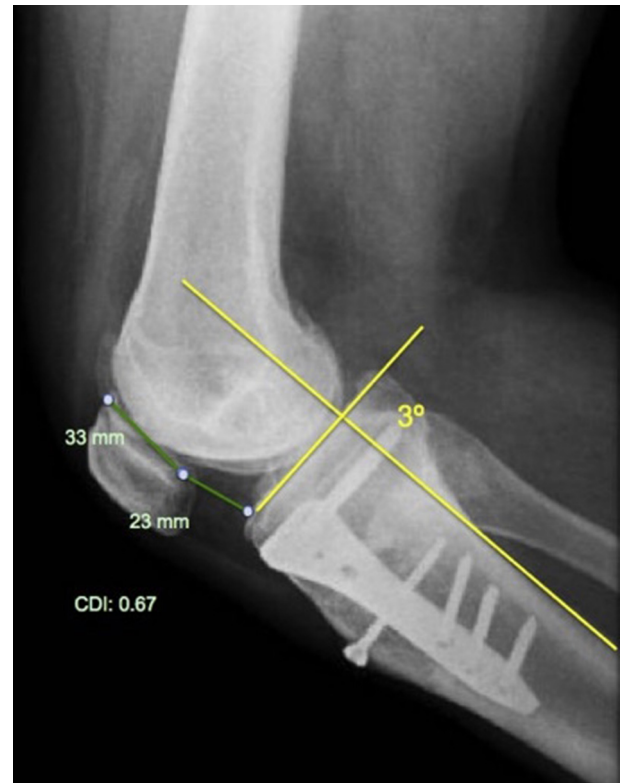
Postoperative radiographic sagittal imaging. Note that neither modification in patellar height nor posterior tibial slope has been made.
